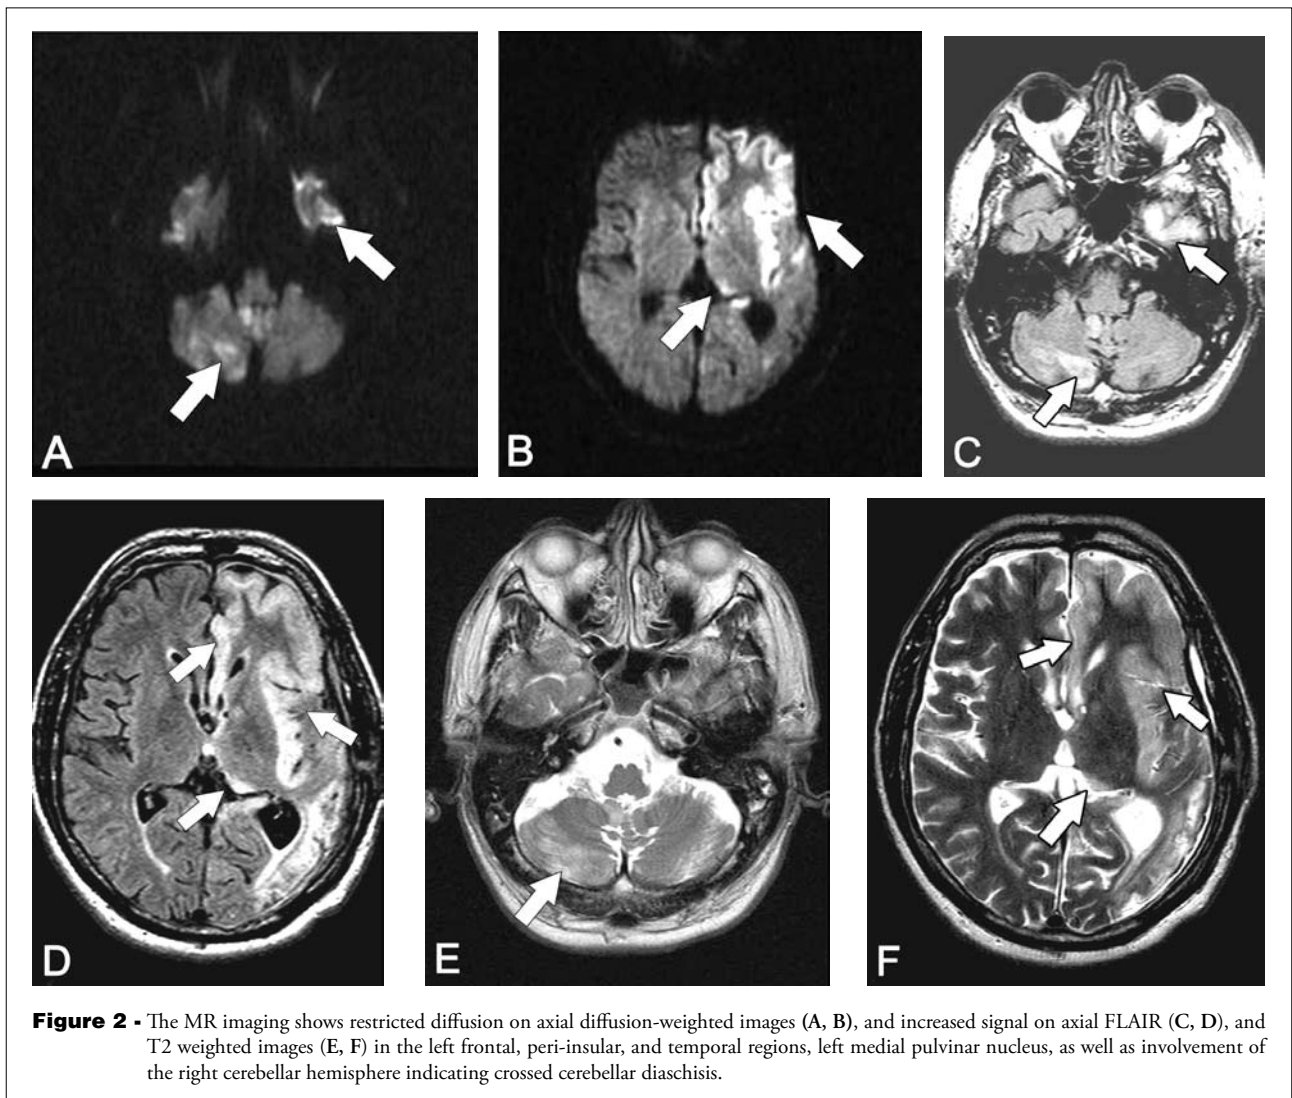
The MR imaging shows restricted diffusion on axial diffusion-weighted images (A, B), and increased signal on axial FLAIR (C, D), and T2 weighted images (E, F) in the left frontal, peri-insular, and temporal regions, left medial pulvinar nucleus, as well as involvement of the right cerebellar hemisphere indicating crossed cerebellar diaschisis.
